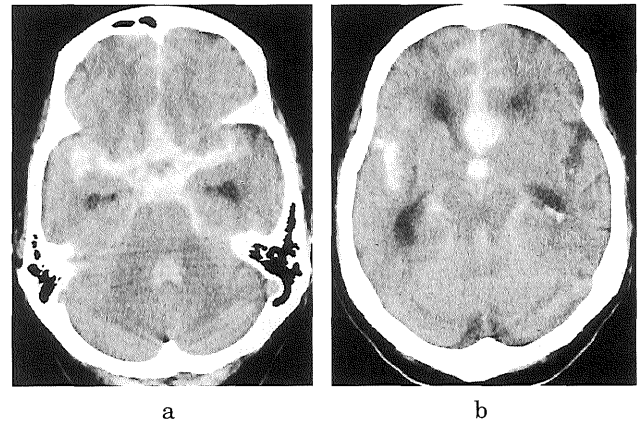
Computed tomographic scan at a point when the patient became comatose, 40 days after detection of the aneurysm, showing severe subarachnoid hemorrhage, thickest in the interhemispheric fissure, in the basal cisterns.
